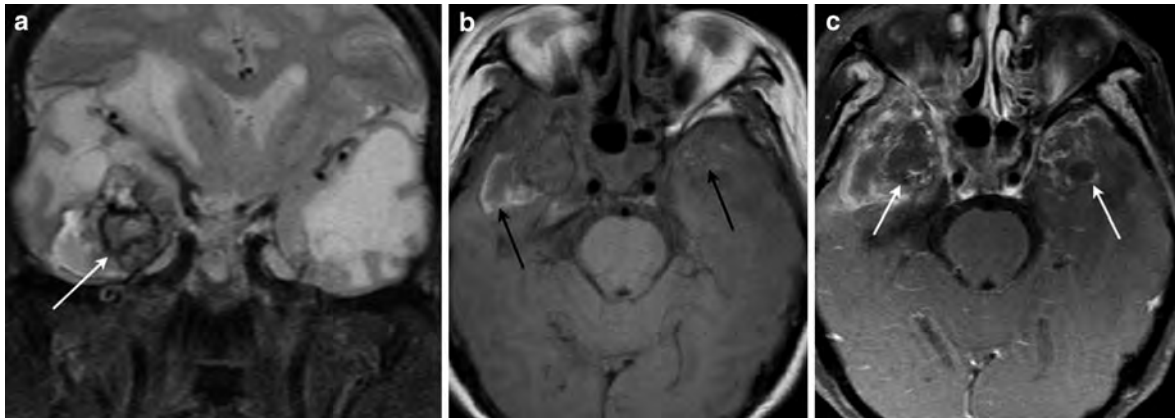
Radiation-induced temporal lobe necrosis. a Coronal fat-saturated T2-weighted MR image shows bilateral cystic temporal lobe necrosis with florid cerebral oedema. The low signal intensities in the right temporal lobe are due to associated haemorrhage (*arrow*). b Axial T1-weighted MR image shows
